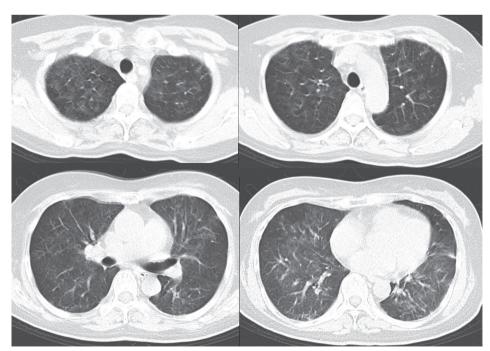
Chest computed tomography, axial view of the lung window, performed about 1 week before admission, when the patient developed fever and exertional dyspnea, revealed diffusively interlaced patches of ground-glass opacities.
